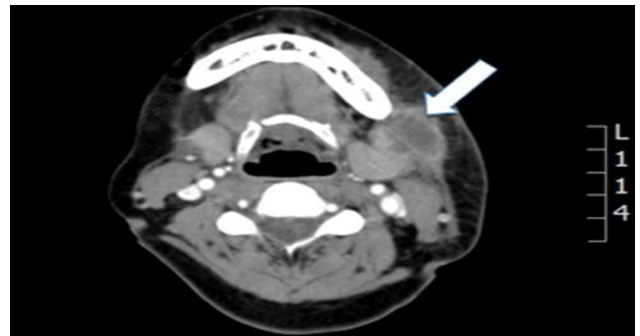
Contrast-enhanced CT scan of the neck demonstrating hypodense abscess within the left masseter muscle (arrow).
